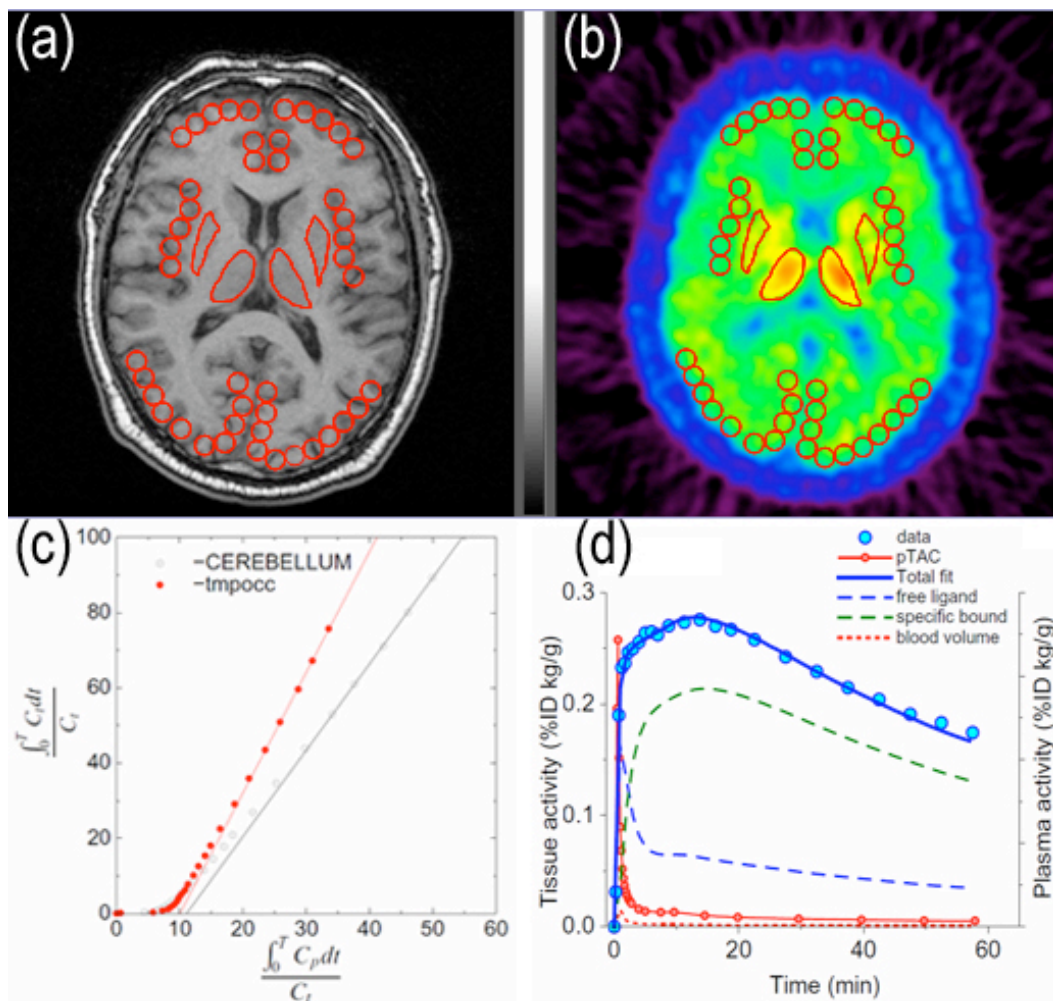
Regions of interest (ROIs) defined in the cerebral cortex and subcortical deep nuclei in the MRI (a) and the co-registered PET image taken from a healthy volunteer subject (b); result of linearization using Logan graphical analysis (c); and time activity curves in plasma and brain tissue for compartmental model analysis (d) are demonstrated.
